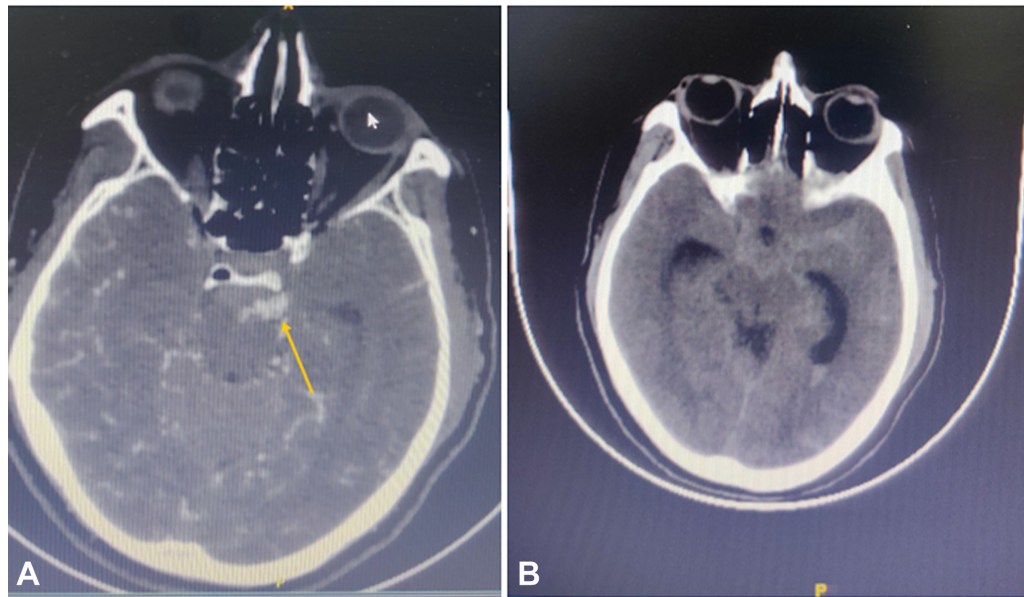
Computed tomography (CT) angiogram showing left superior cerebellar artery aneurysm (A) and CT brain plain showing subarachnoid hemorrhage (SAH) in cisternal and other subarachnoid spaces along with intraventricular hemorrhage (IVH) (B).
